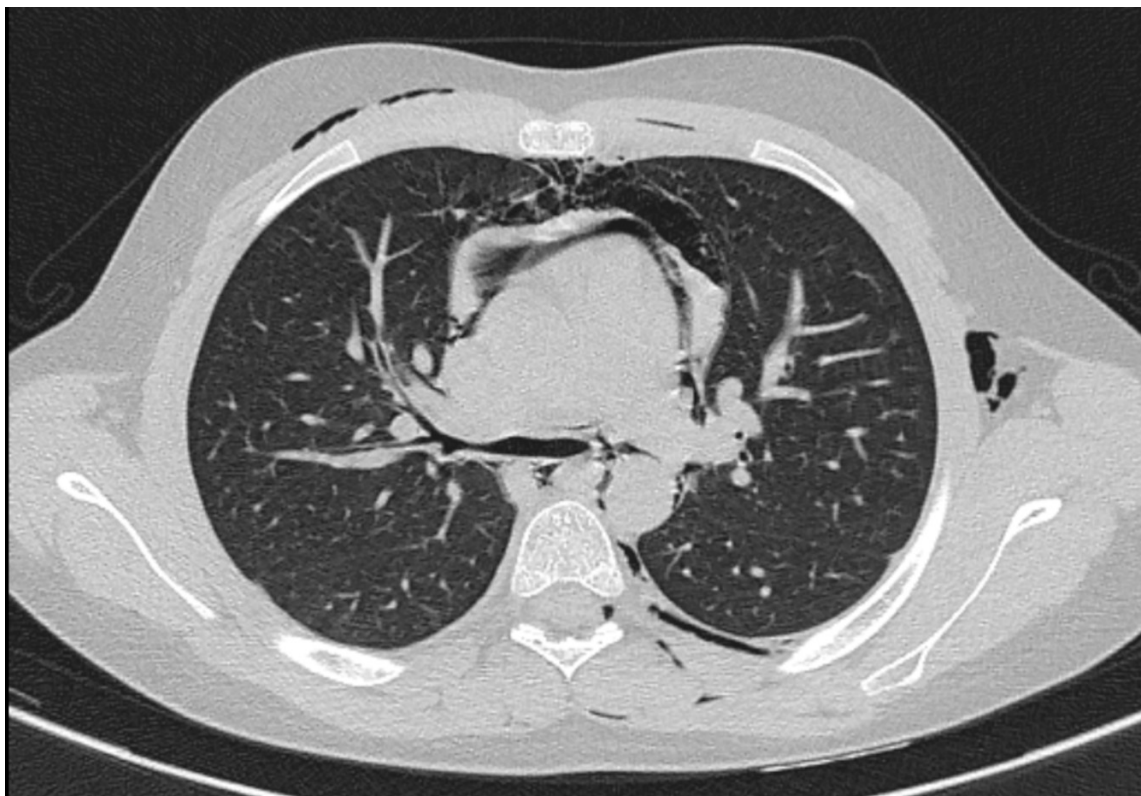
CT shows the presence of air in vertebral canal in epidural space.
